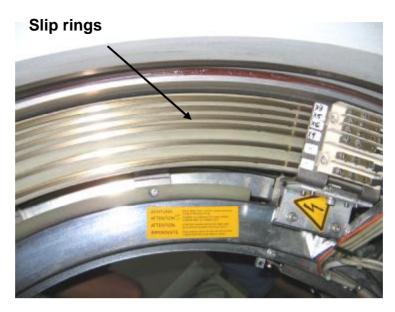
The use of the slip ring technology to transmit out the data from the moving part Picture taken of CT Siemens Somatom Plus 4
